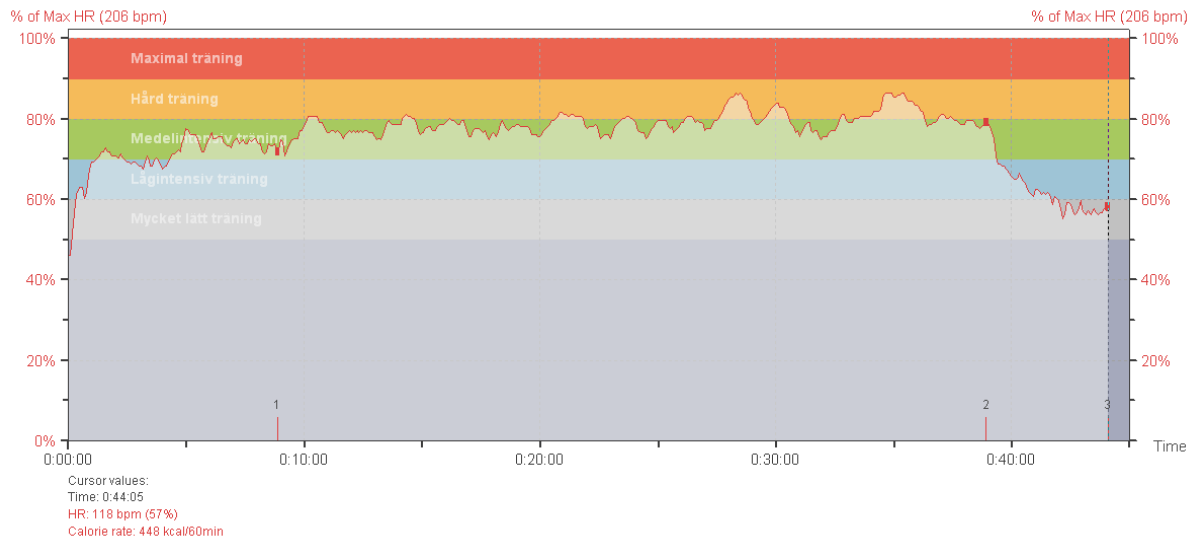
HR recording during a CT session in week 1.
